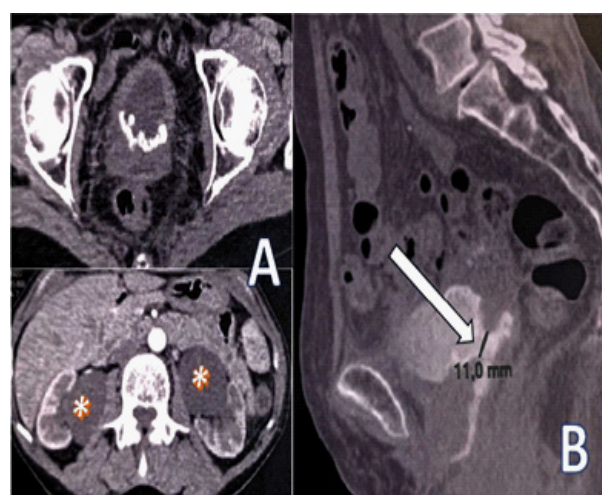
CT abdomen and pelvis sections.
